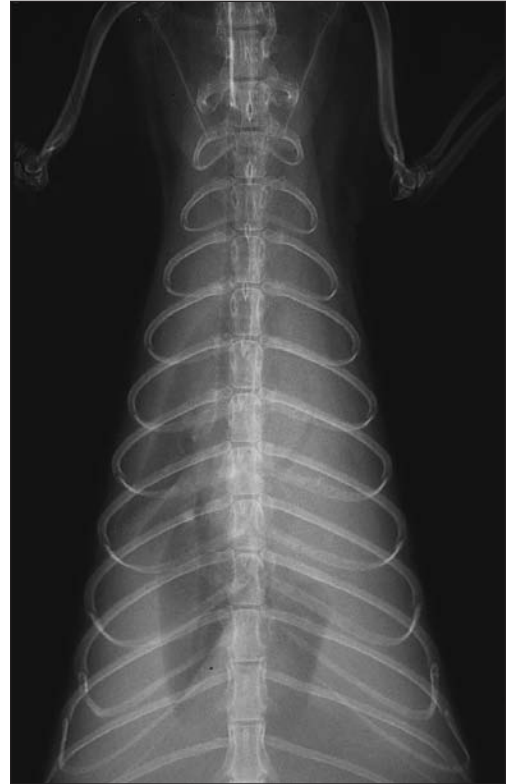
Lateral (left) and ventrodorsal (right) radiographic views of the thorax of a ferret evaluated because of acute onset of labored breathing.
